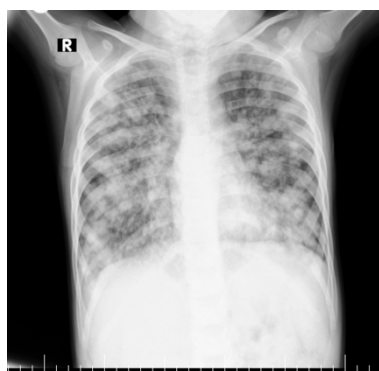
Chest X-ray (16th of February)
